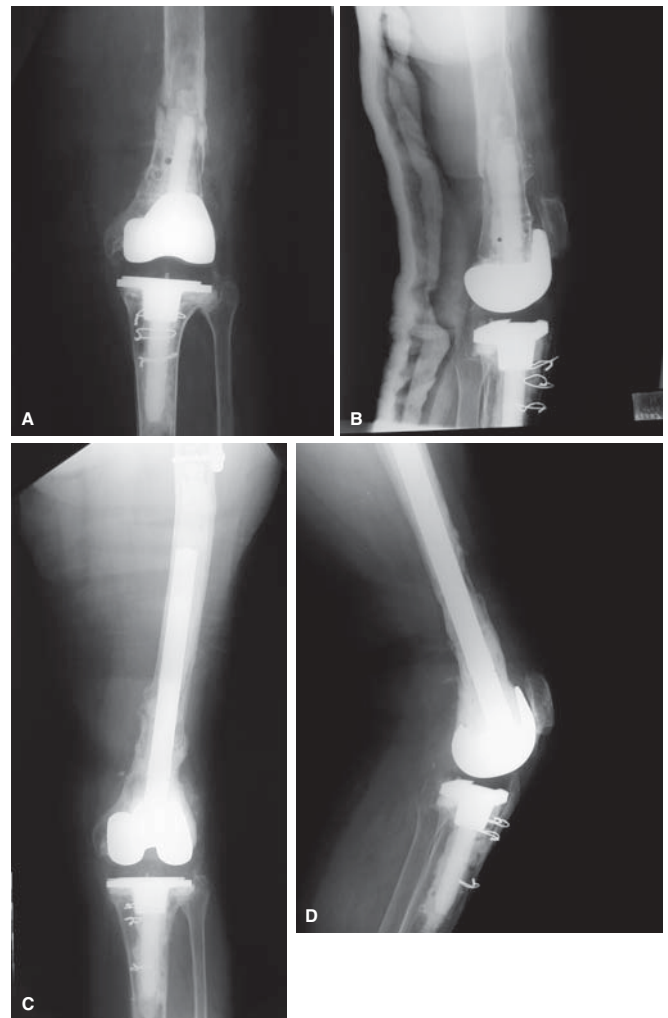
Case 2. Anteroposterior and lateral radiographs (A and B, respectively) showed nonunion above a stable stemmed component after osteosynthesis on the left knee. One and a half years after revision, anteroposterior and lateral radiographs (C and D) showed union and good alignment of the component
